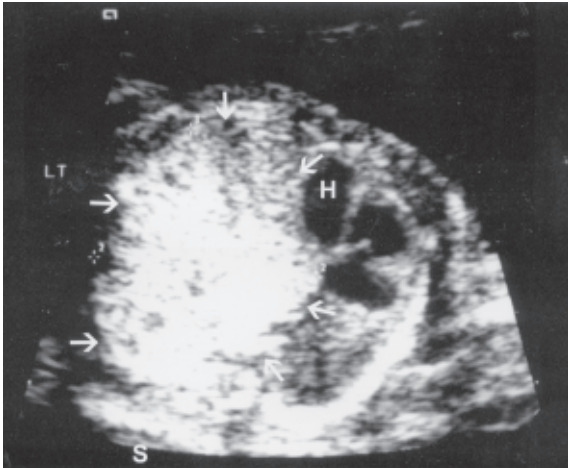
Transverse ultrasonogram of the foetal thorax (case 4) shows an echogenic lung mass (arrows) displacing the foetal heart (H) to the right. (S: spine)
